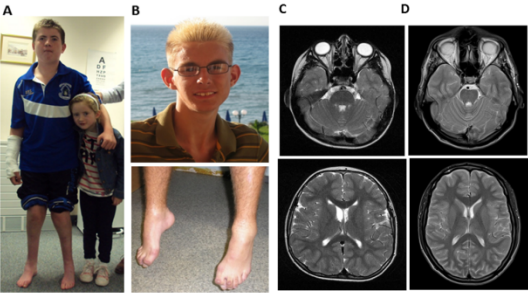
Clinical presentation of patients 1, 2 (A) and 3 (B) presented in this study. Brain MRI of patient 1 (C) and 3 (D) detected bilateral, symmetric hyperintensities in the posterior pons and medullary region.
